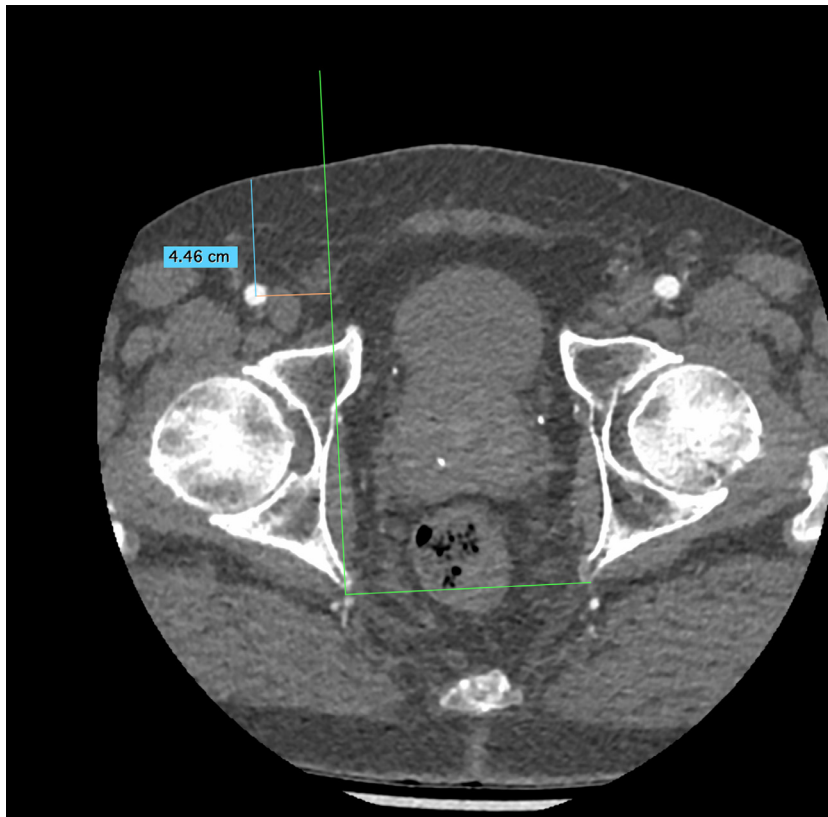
Axial CT slice passing through the geometric center of the femoral heads. First, a horizontal line was drawn between the ischial spines (green line). An orthogonal vertical line (green line) was drawn from this bi-ischiatic line and directed anteriorly. Another orthogonal horizontal line (pink) connected the vertical line to the geometric center of the common femoral artery that was used as a vascular access (the right one in the present case). Finally, a second vertical line (blue) was traced from the center point of the common femoral artery to the skin surface.
